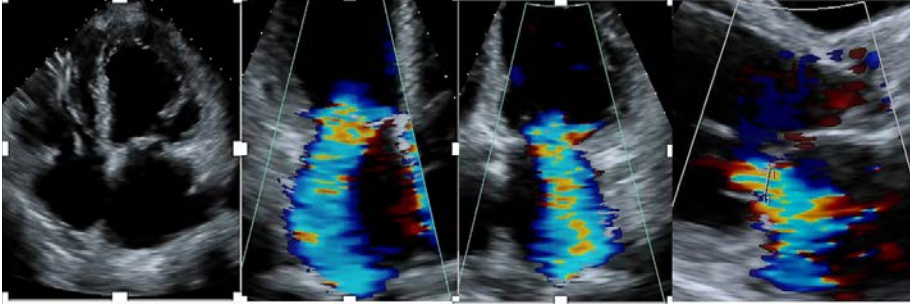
Functional mitral regurgitation in heart failure. The image on the far left shows a four chamber view of the heart. The next three images show the severity of mitral regurgitation as assessed by colour Doppler in the three chamber view, four chamber view and long axis parasternal view, respectively.
